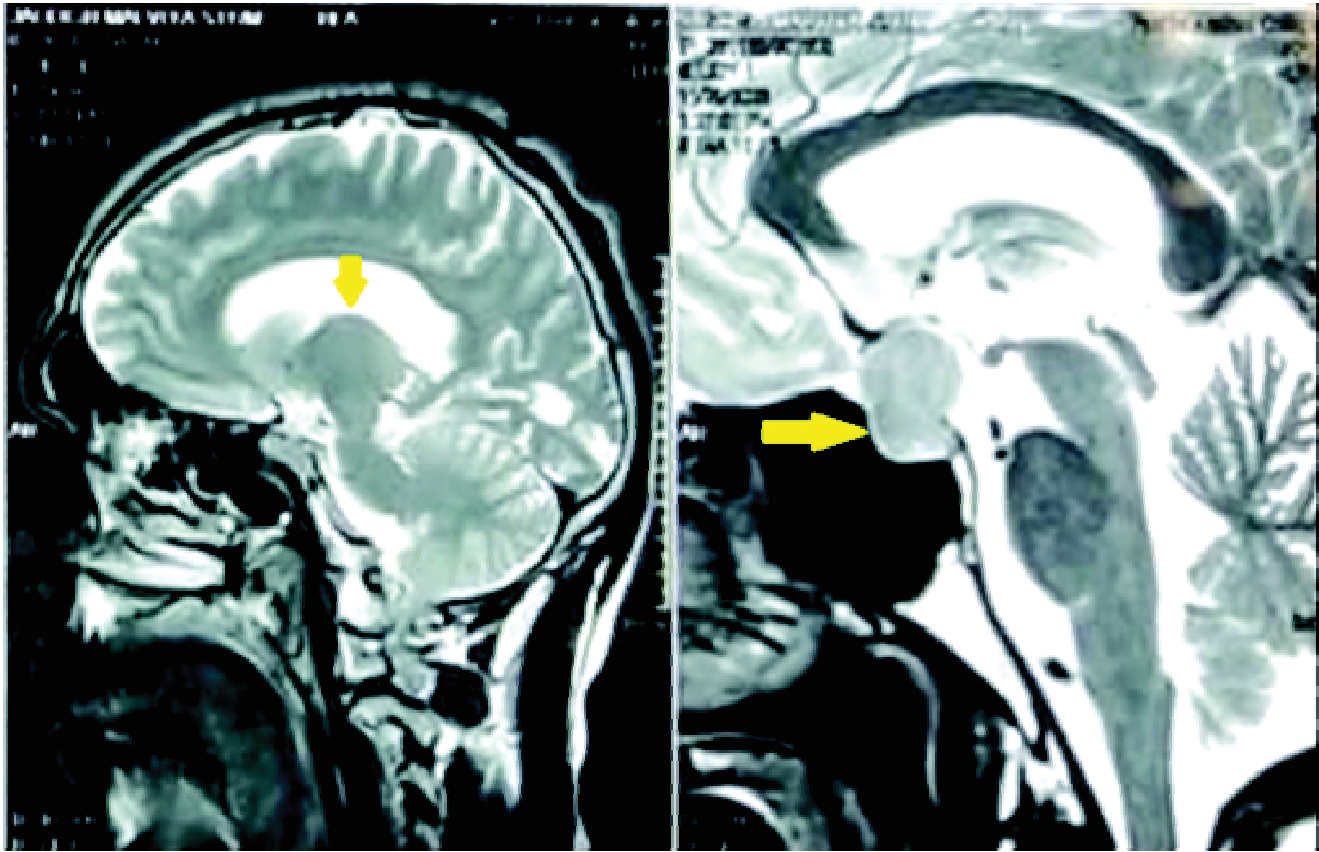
MRI pituitary showing Macroadenoma with suprasellar and parasellar extension and compression of Optic chiasma.
